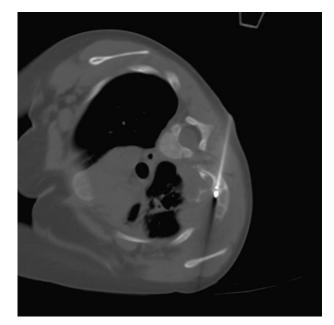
Radiofrequency thermoablation of the lesion under CT guidance.
